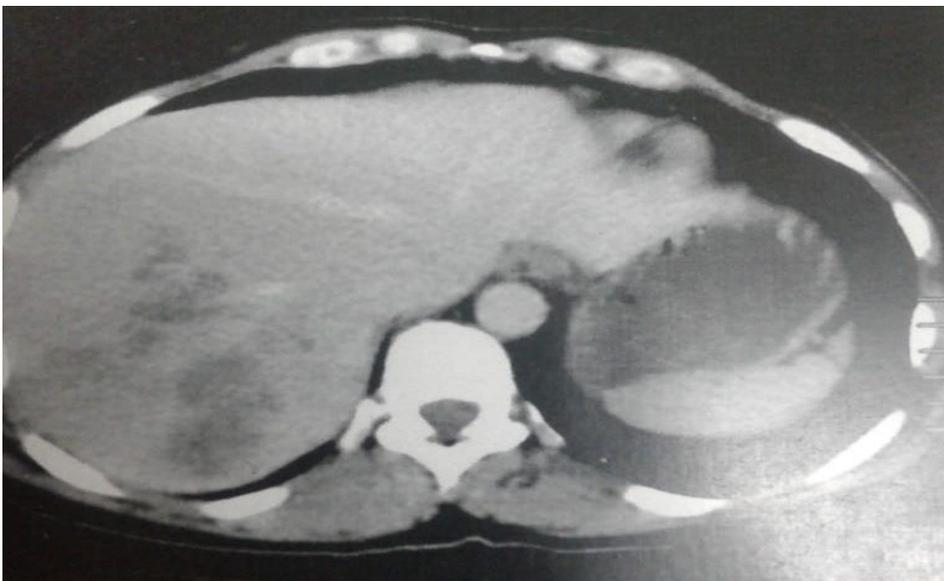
Abdominal CT showed hypo-dense branching focal lesions in segments 7 and 8 in liver
